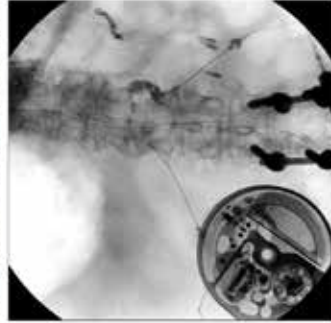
Radiographic image of fluoroscopically-guided retrocrural celiac plexus block.
